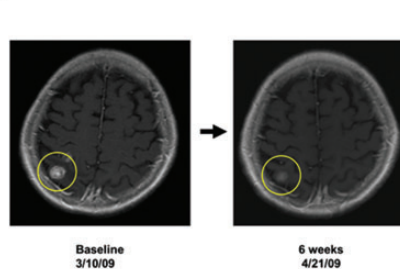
(A) 3DWaterfall plot showing best response as determined by Response Evaluation Criteria in Solid Tumors (RECIST) and the time on study in all 26 breast cancer patients treated. The patient who withdrew before first restaging due to grade 3 diarrhea and any patients with clinical progression or new lesions are arbitrarily depicted as 21% increase by RECIST and are considered treatment failures. Patients with non-measurable disease that achieved best response of stable disease (SD) are depicted in the figure as +0.5%. None of the patients had prior cetuximab or erlotinib. The patient with a PIK3CA mutation is noted as such. The dose level for each patient and the number of months the patient received treatment on study are shown in the table above the waterfall plot. Patients still on treatment have a '+' after the number of months and are indicated with an arrow (>) on the black bar for that patient. (B) Patient with partial response (36% decrease, seven prior systemic therapies) on treatment for 6 months. (i) and (ii) computed tomography (CT) scans showing decrease in size of liver metastases. (C) Patient with partial response (86% decrease, three prior systemic therapies), (i) CT scans showing decreased size of lung metastases, (ii) response in skin metastases. (D) Patient with brain metastases only and partial response (30% decrease, six prior systemic therapies), CT scans showing the decrease in size of brain metastases.
